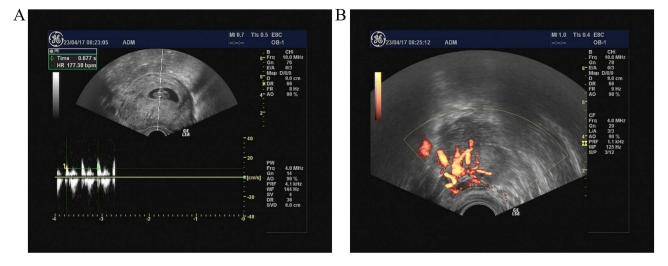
The ultrasound examination I day after laparoscopic surgery: (A) a live fetus in the uterine cavity; (B) the right ovary measured 5.1×3.4 cm with abundant internal blood flow signal.
